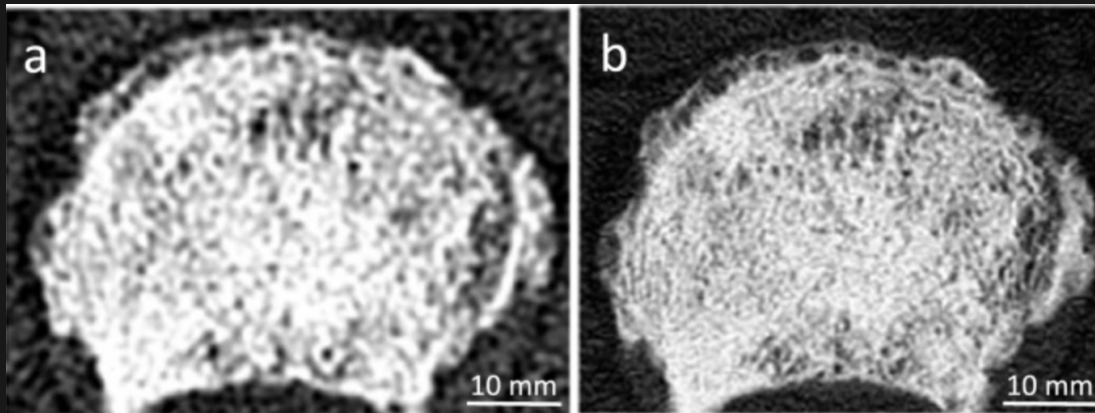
Images of osteoplastic metastasis of 5th lumbar vertebra, visualized by conventional CT (a) and PCD-CT(b).
